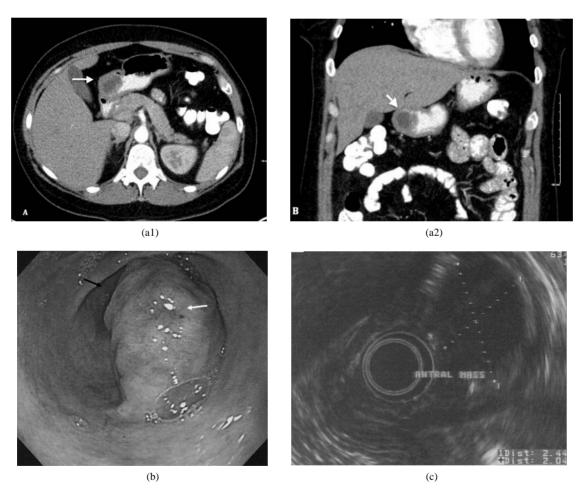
(a): Axial (1) and coronal (2) contrast-enhanced computed tomography (CT) images revealing a 3.2×2.3 cm non-enhancing, partially necrotic mass (white arrows) in the gastric antrum located just proximal to the pylorus; (b): Eso-phagogastroduodenoscopy (EGD) image demonstrates a 3 cm subepithelial gastric mass with a lobulated contour located immediately proximal to the pylorus (black arrow) covered by glistening pink mucosa with an erythematous focus (white arrow); (c): Radial endoscopic ultrasound image revealing intact gastric wall layers. The well-demarcated antral lesion (dotted X) represents a 2.4×2.0 cm homogeneous, hypocheoic mass that arises completely from within the submucosal layer.
